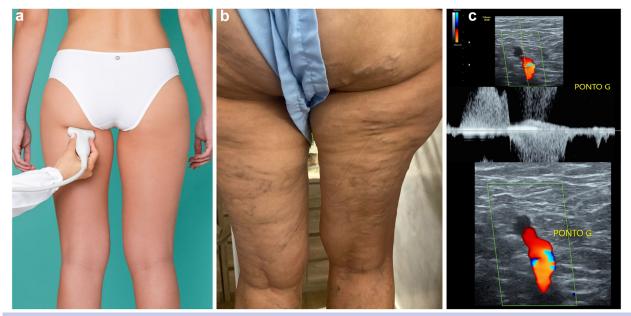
A. Location of the gluteal escape point on transperineal ultrasound examination. B. Gluteal and posterior thigh varicose veins C, Gluteal escape point with reflux on color Doppler. Authors archive.
